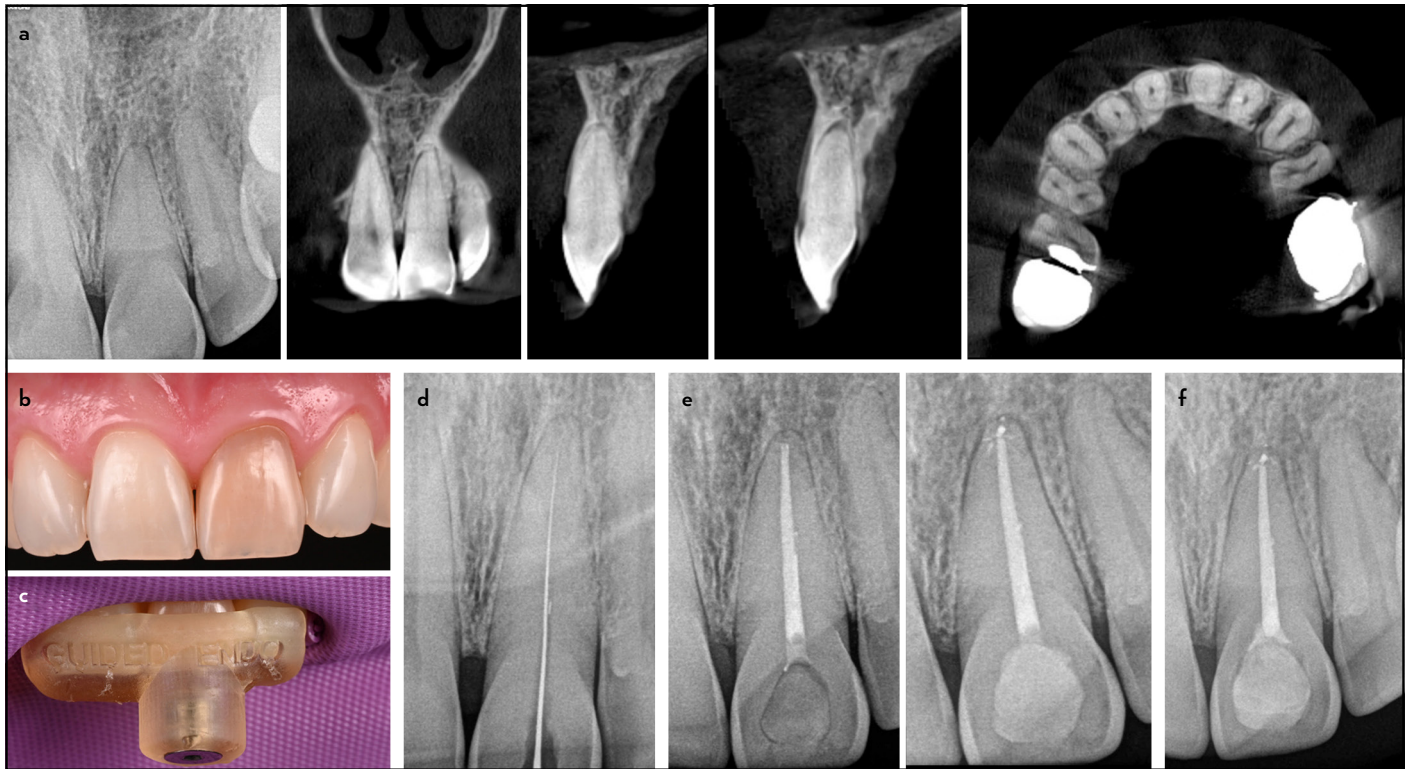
Case 8. (a) Pre-operative radiograph and CBCT scan showing the degree of root canal obliteration and the periapical lesion. (b) Tooth crown discoloration. (c) Template fitting and placement. (d) Radiograph confirming root canal access. (e) Immediate postoperative status and follow-up radiograph at one week showing definitive restoration. (f) Follow-up at one year and three months
